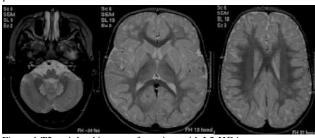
T2-weighted images of a patient with L2-HGA
